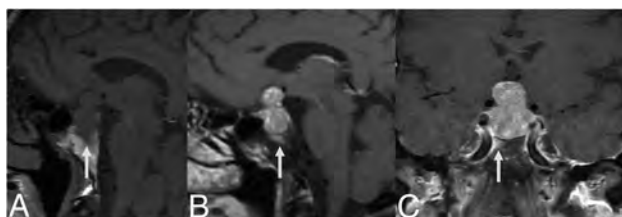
A large pituitary adenoma on precontrast sagittal T1-weighted (A), postcontrast sagittal (B), and coronal (C) T1-weighted images shows focal bone marrow enhancement in the right anterior and lateral aspect of the basisphenoid. This is a distinct pattern from the diffuse enhancement in patients with GH.
